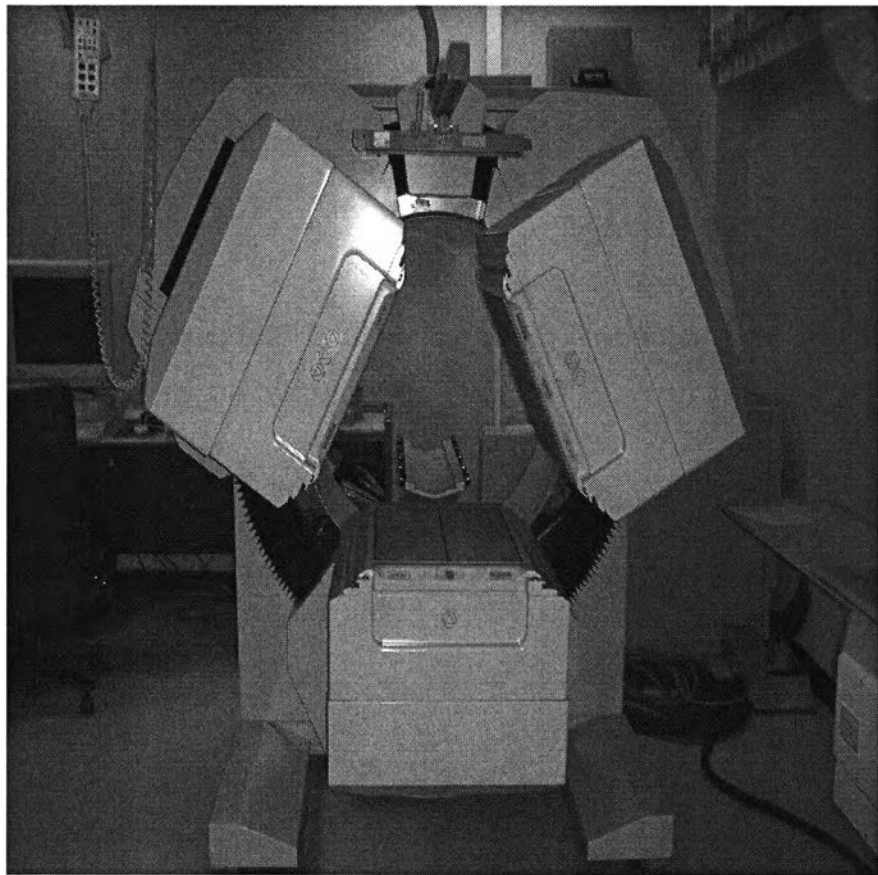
Single Photon Emission Computed Tomography
